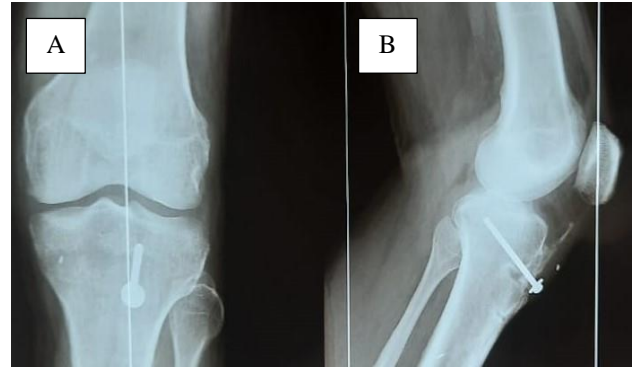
A) 1 year follow up anteroposterior and B) lateral X-ray of left knee joint suggestive of bony union of tibial tuberosity fragment.
